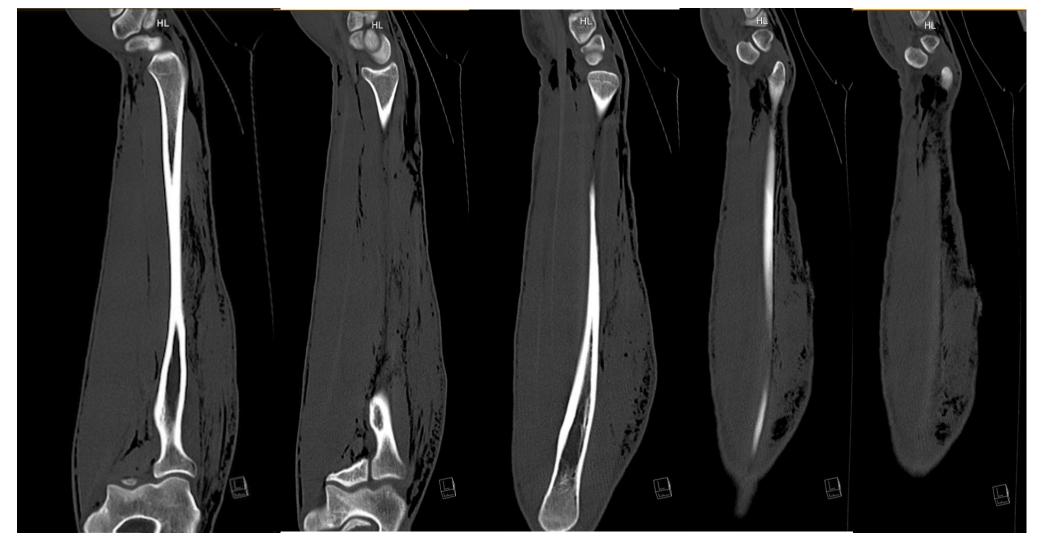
Day of trauma: CT performed showing extensive SE on forearm and wrist
